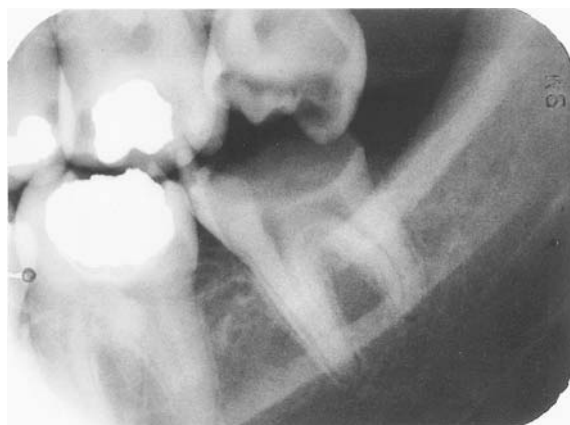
Mandible: molar periapical image.
